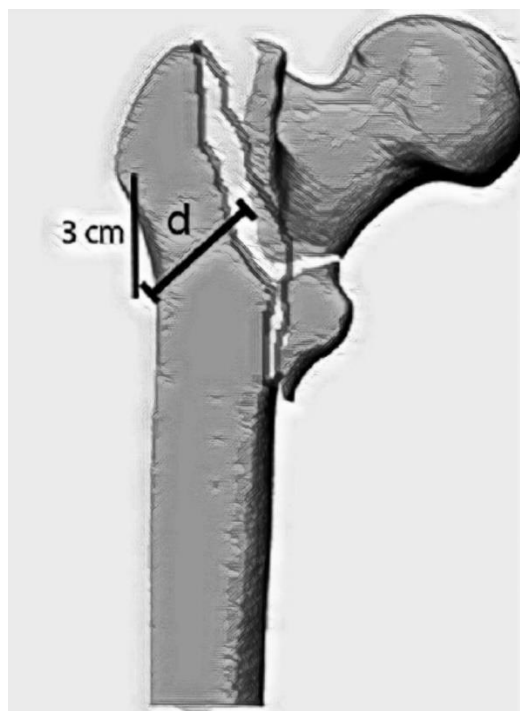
The thickness of the lateral trochanteric wall. A line is drawn from the greater trochanter's innominate tubercle angled at 135° upward to the fracture on anteroposterior radiograph. The distance between the lateral wall and the fracture line (d) represents the lateral wall thickness. A distance less than 20.5 mm is considered a fracture with a thin lateral wall.
